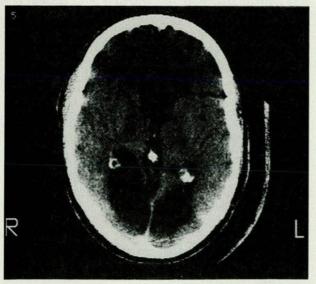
Computed tomographic scan reveals large, bilateral occipital lobe infarctions, which are represented by the large areas of decreased density in the lower portions of both cerebral hemispheres (case 3).
